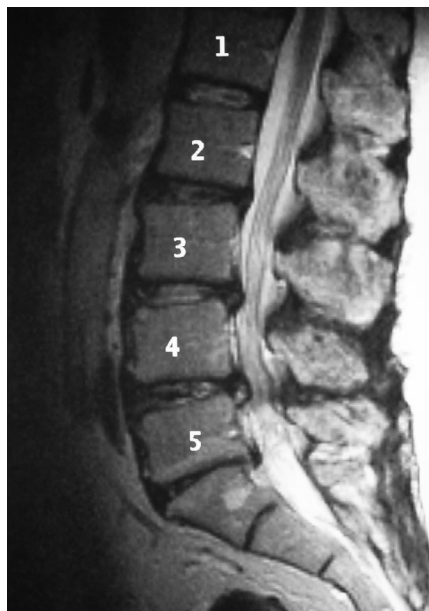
Preoperative evaluation using MRI.
